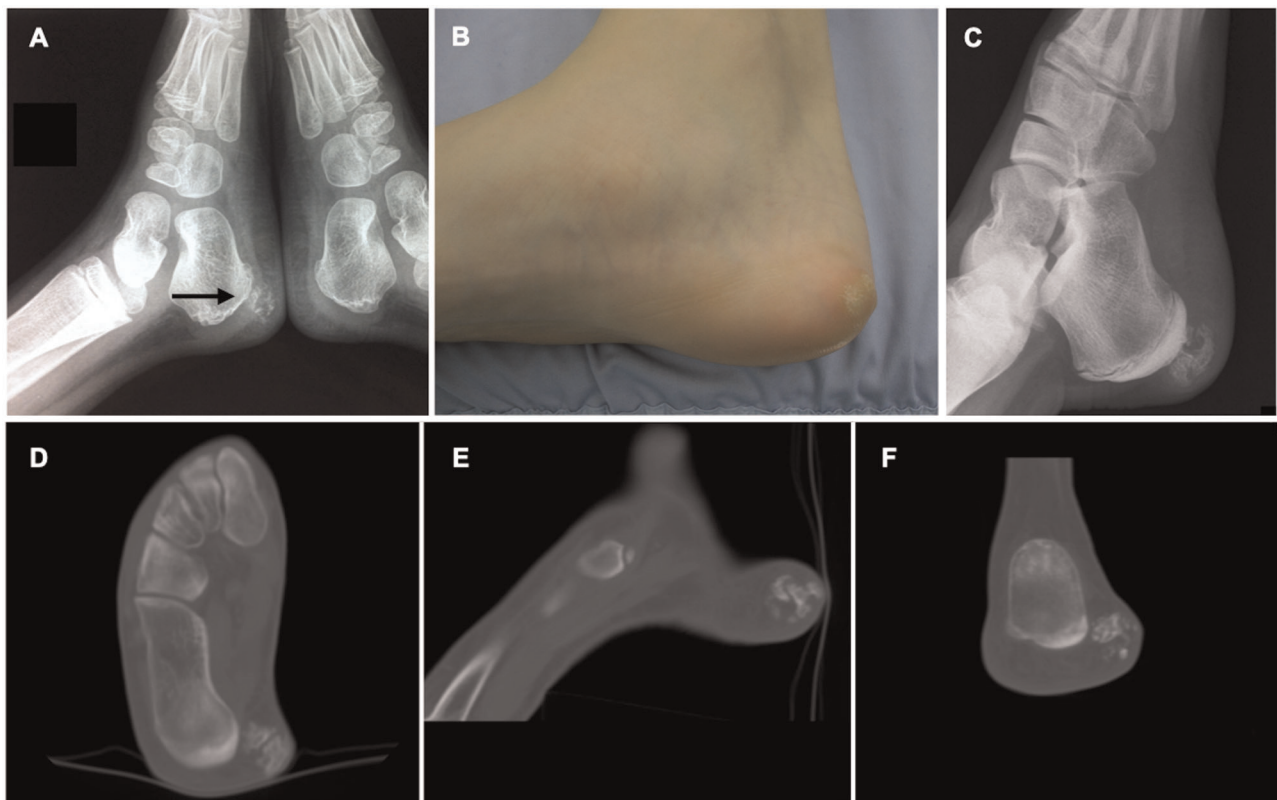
(A) Old X-ray showing the clinically silent lesion at the age of 6 years. (B) Clinical picture showing the mass covered with areas of hyperkeratosis. (C) New X-ray at time of presentation showed increased size of the lesion. (D–F) Preoperative CT section of the lesion.
